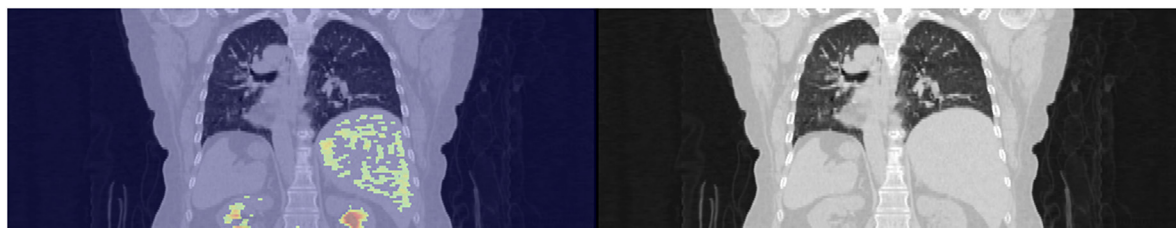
Extraction of the 3D images of the lungs with a thickness of 96 slices of trans-axial CT images.
